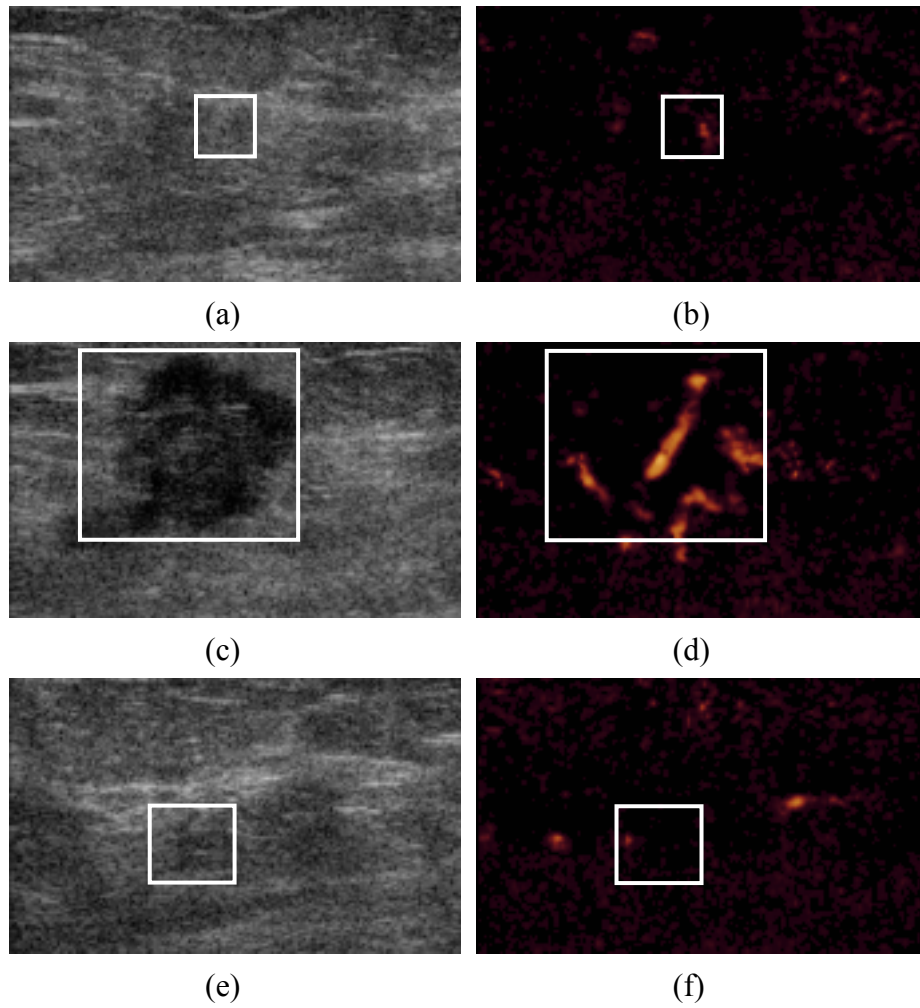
Physician manual selected ROI (white rectangle) of specific slice for B-mode ultrasound and power Doppler ultrasound: (a)-(b) the first slice with corresponding power Doppler image slice, (c)-(d) the middle slice with corresponding power Doppler image slice, and (e)-(f) the last slice with corresponding power Doppler image slice.
